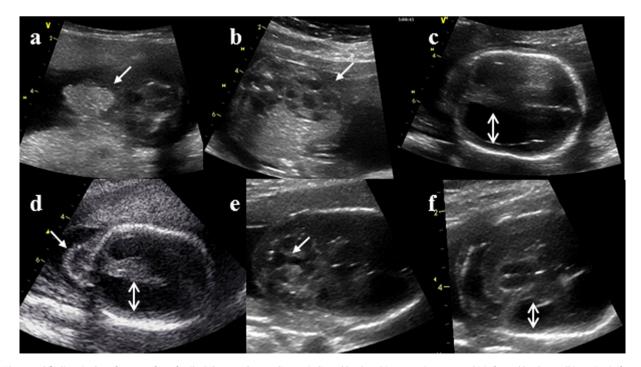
Ultrasound findings in three foetuses of one family. (Ultrasound anomalies are indicated by the white arrows). a: gastroschisis formed by the small intestine in foetus 1 (F1). b: multicystic left kidney in foetus 2 (F2). c: ventriculomegaly in foetus 2 (F2). d: occipital meningocele in foetus 2 (F2). e: cerebellar vermis agenesis, dilated IV cerebral ventricle in foetus 3 (F3), f – ventriculomegaly in foetus 3 (F3).
